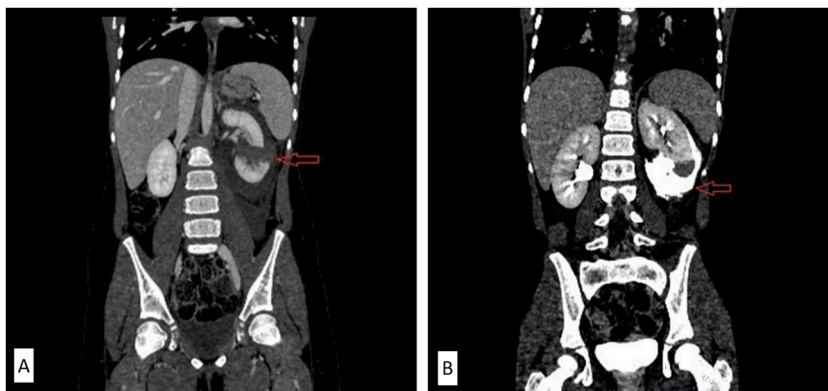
A–B: A: Initial coronal CT in portal venous phase revealed a complete transection of the left kidney with the distraction of the poles (red arrow); B: Delayed phase at initial CT was done to assess the injury of the collecting system of the left kidney and showed extravasation of contrast with the presence of perinephric urinoma (red arrow). (For interpretation of the references to color in this figure legend, the reader is referred to the Web version of this article.)
